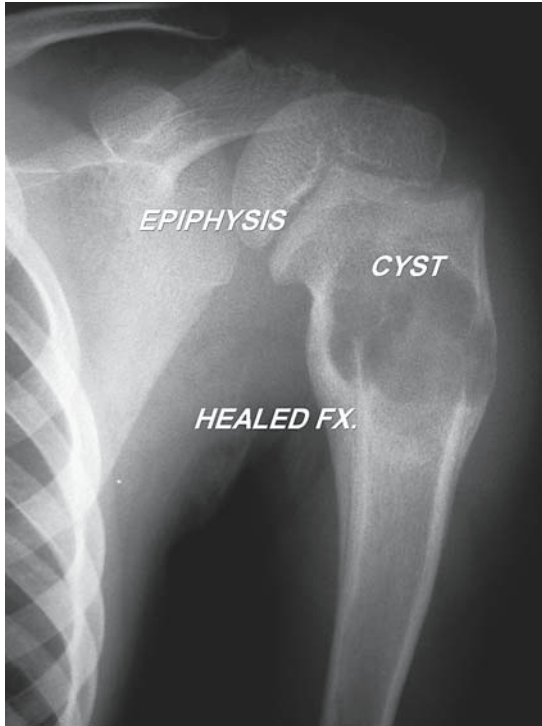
Unicameral bone cyst (UBC). AP radiograph demonstrates a UBC in the proximal humerus of a skeletally immature patient. This lesion has a well-defined border and a narrow transition area that is often associated with a reactive sclerosis. The lateral cortex is thin but appears intact; this is the most common site for UBCs to arise.
